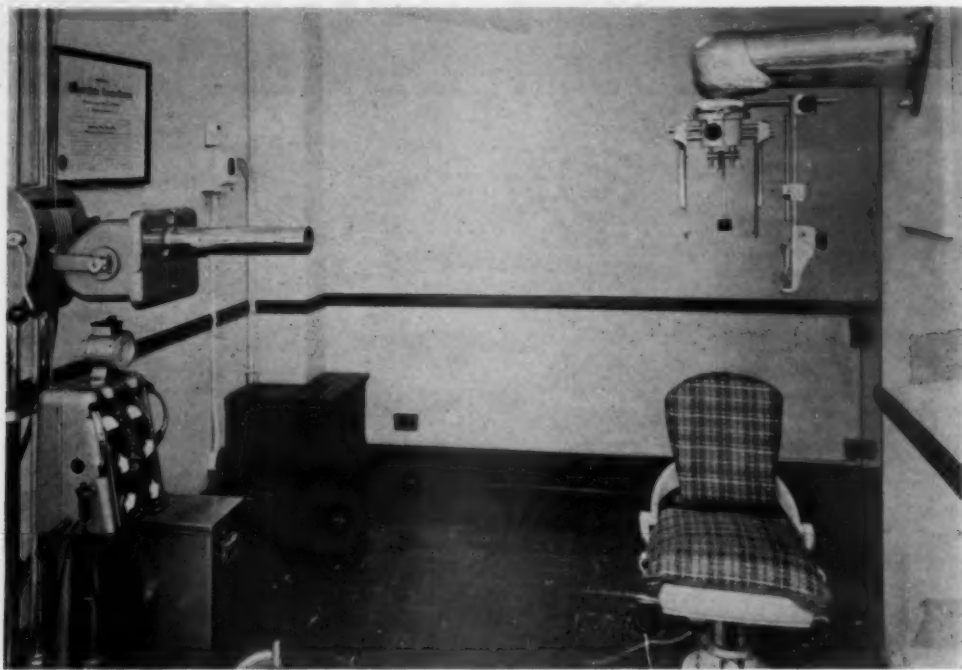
Photograph of author's roentgenographic cephalometric equipment.
